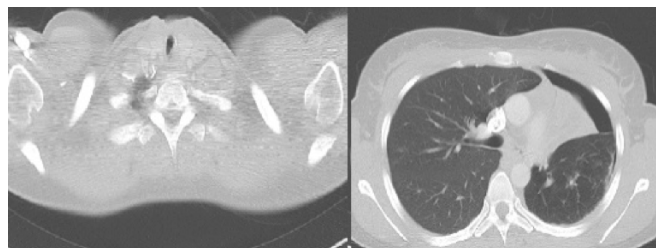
Thorax CT images showing the post-intubation stenosis in the trachea, stenosis in the left main bronchus, total atelectasis in the left upper lobe, and partial pneumothorax.
